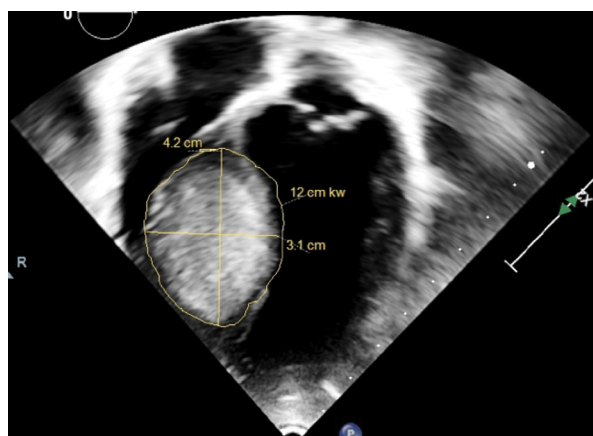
Two-dimensional echocardiography, four-chamber projection. A 4.2×3.1 cm tumour with a surface area of 12 cm^2 , protruding into the right and left ventricle is present in the interventricular septum
